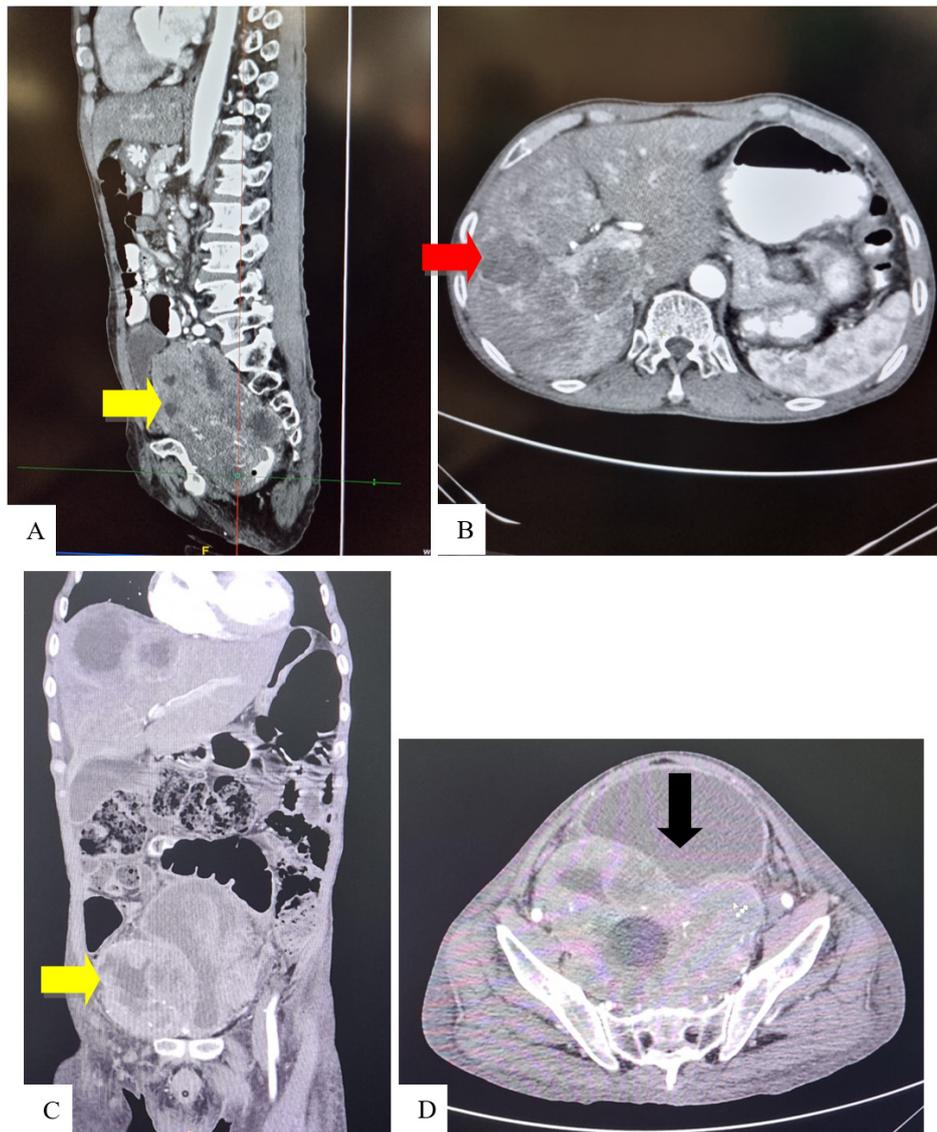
Abdominal contrast computerized tomography (CT) scan. (A) & (C) An isodense and inhomogeneous mass with poorly circumscribed and irregular border (yellow arrow); (B) Multiple hypodense and inhomogeneous nodules in the liver (red arrow); (D) Trilobed sign (black arrow).
